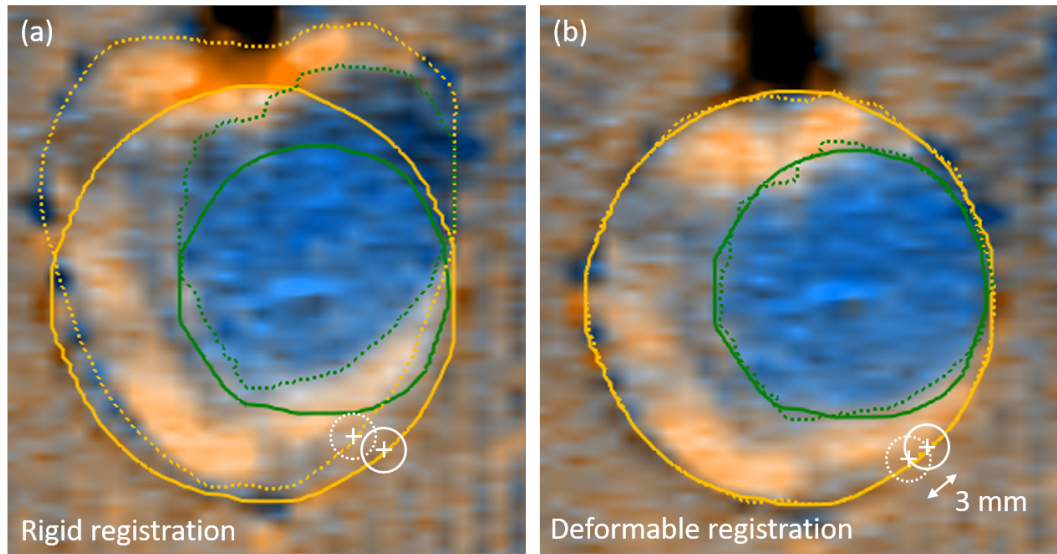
Images showing CT (blue) and ADC maps (orange) following (a) rigid registration (i.e. the original images are overlaid) and (b) deformable registration. Bladder delineations are shown in yellow and tumour in green with CT delineation indicated by solid lines and ADC by dotted lines. An example of POI differences along the bladder surface is indicated with white cross-hairs. Note that whilst contours closely align following DR, there remains a 3 mm difference along the bladder surface.
